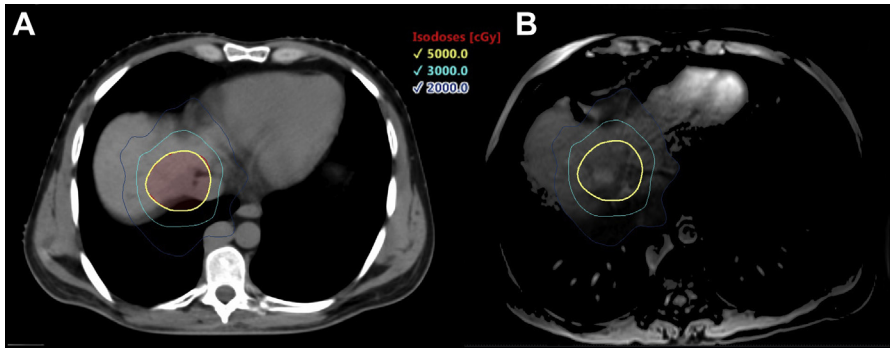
SBRT as bridge to transplantation. A35-year-old man with a history of Budd-Chiari-related cirrhosis who developed a cT1N0M0 HCC next to the right liver dome. AFP was 1872. He underwent TACE in 7/2018 but subsequent imaging and post-TACE AFP of 1613 indicated residual disease. He completed a course of SBRT involving 5000 cGy in 5 fractions. (A) SBRT plan on planning CT. Isodose lines represented in absolute dose (cGy). (B) SBRT plan projected on pretreatment MRI abdomen. The patient's AFP nadired to 2.8 in June, 2019, and he underwent transplant on June 26, 2019. Post-transplant pathology showed 100% necrosis with complete response.
